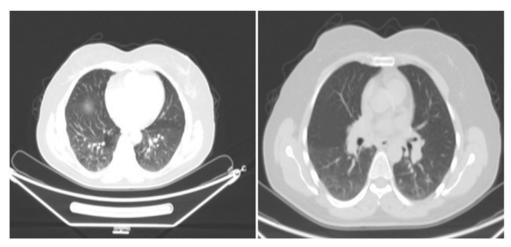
Case 1 Thorax CT Sections.
